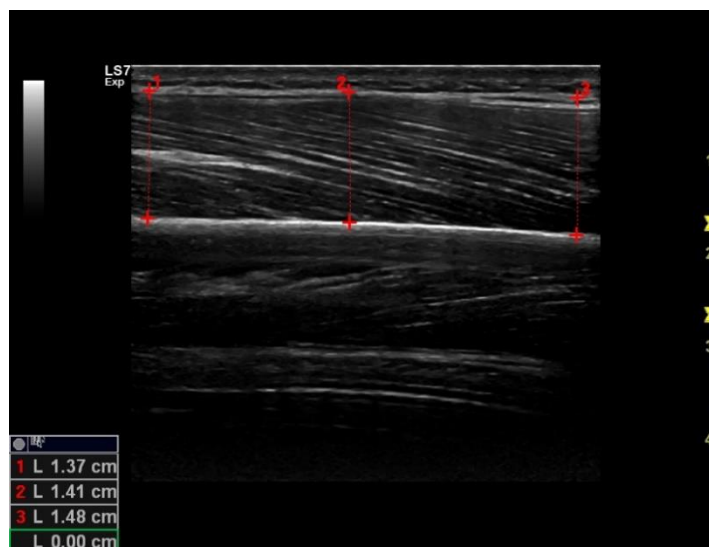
Sample of evaluation of triceps muscle thickness in one ultrasound image snapshot manually. Thickness was evaluated in cm, it is the average of three values: proximal, middle and distal measurement
